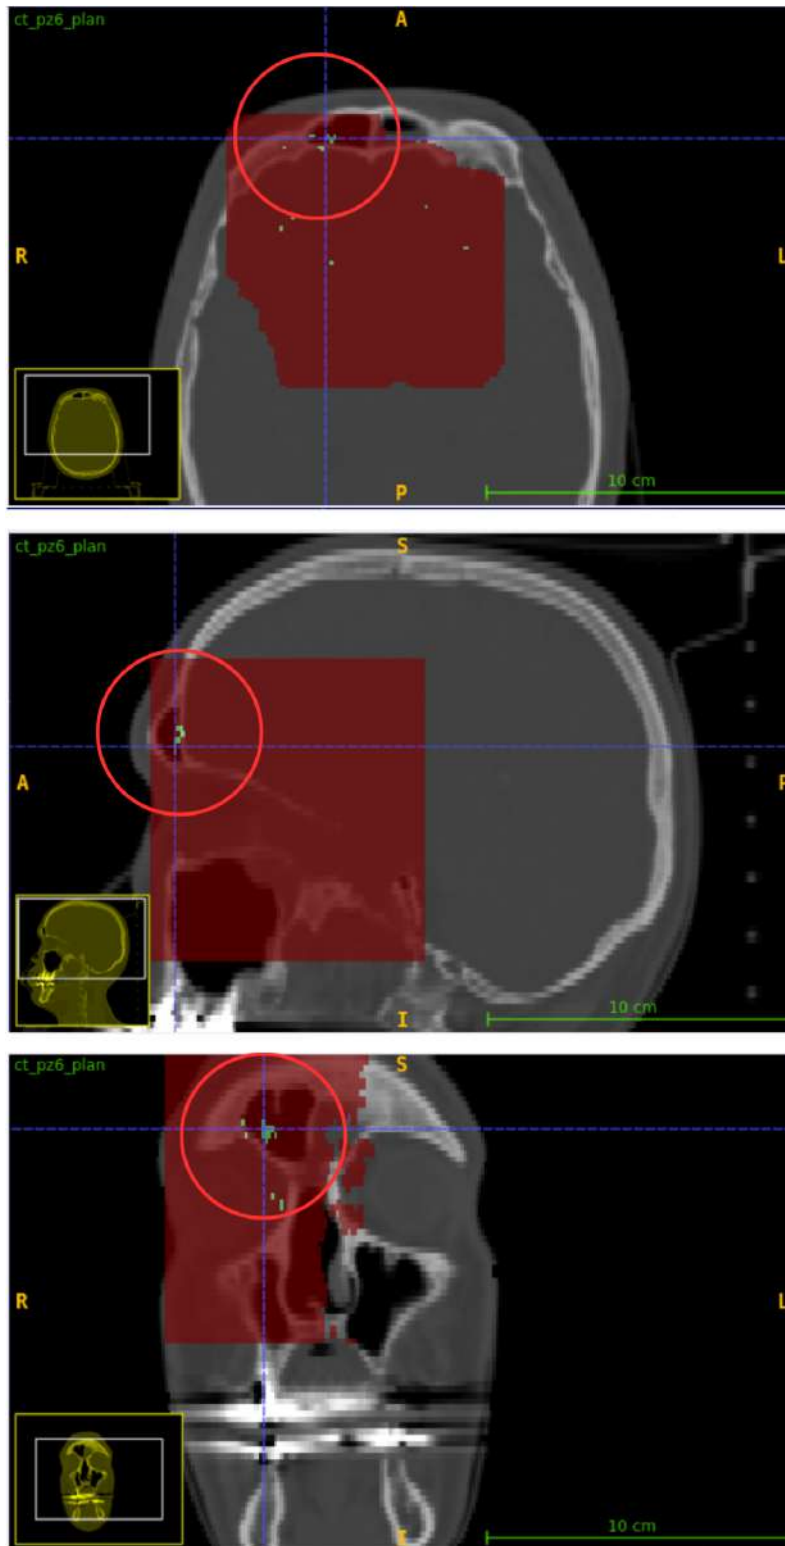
Pass rate map for  $DD = 1.5\%$ ,  $DTA = 20\text{ mm}$ ,  $DTH = 0\%$  in axial, sagittal and coronal views (from top to bottom), overlaid on the planning CT. Only the small morphological variation is detected (red circle), whereas the larger morphological change is not identified.
